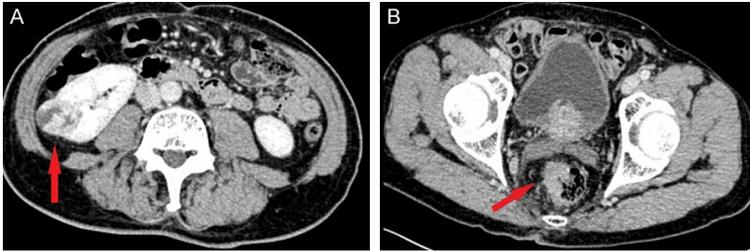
Abdominal CT image. A: There is a low density shadow can be seen on the right kidney which the edge is obviously strengthened (arrows). B: The right wall of the rectum was unevenly thickened (arrows).
